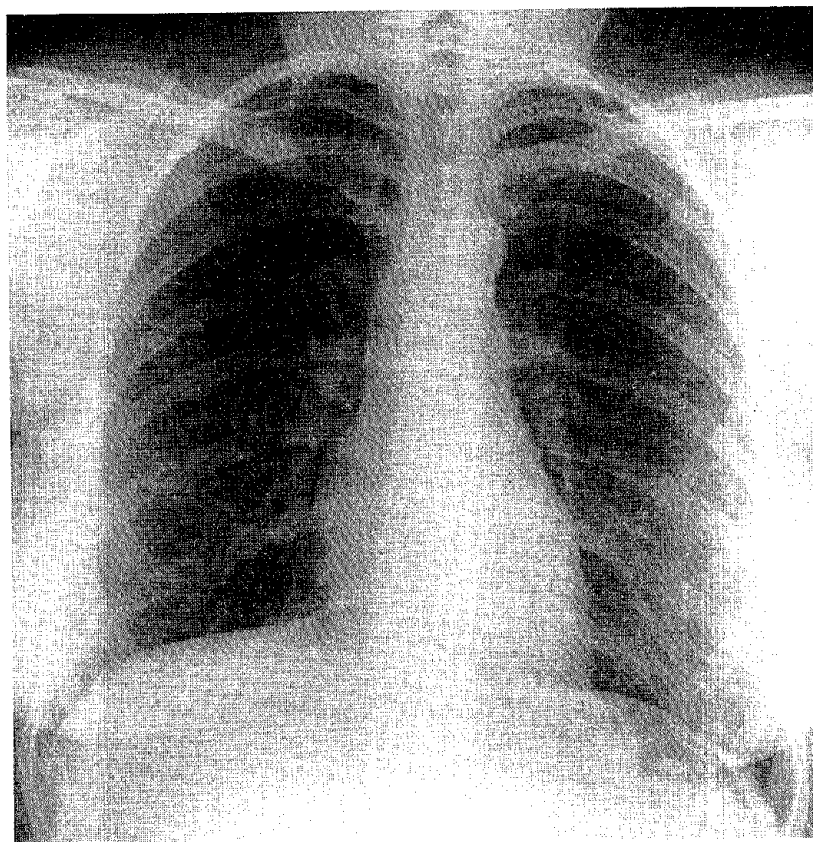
Correct position, posteroanterior chest radiograph, full inspiration.
